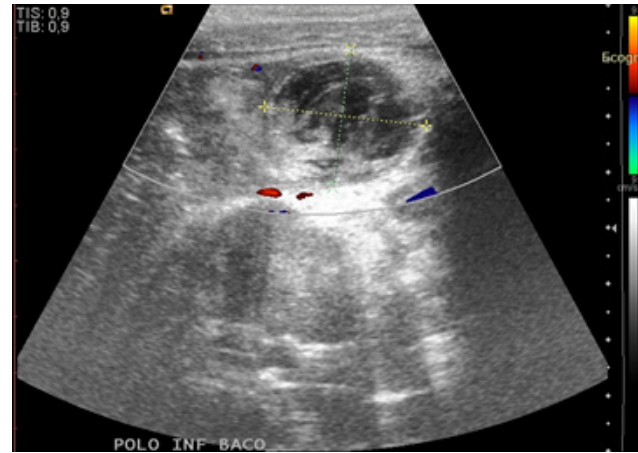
Doppler US. Thrombosed pseudoaneurysm with no internal vascularization.
